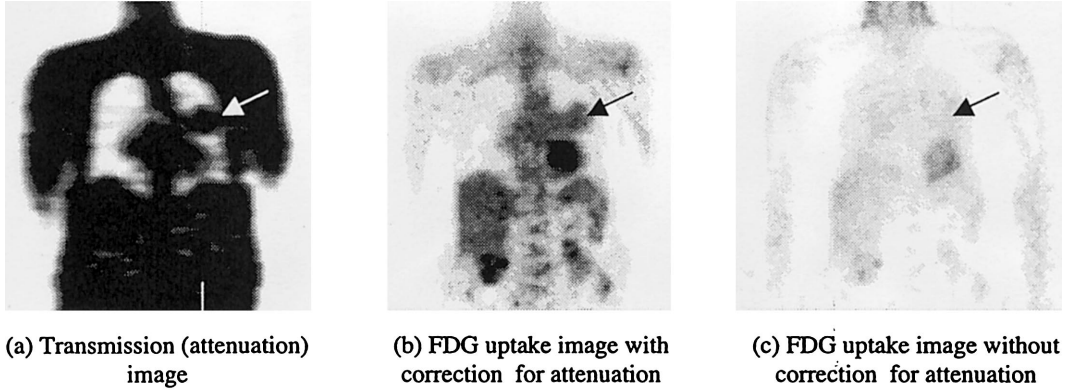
Example of FDG uptake with and without attenuation correction. (a) A harmatoma (arrow) is visible in the transmission image, also called an attenuation image, and (b) in the FDG image with attenuation correction, but is not visible (c) in the FDG image without attenuation correction.
